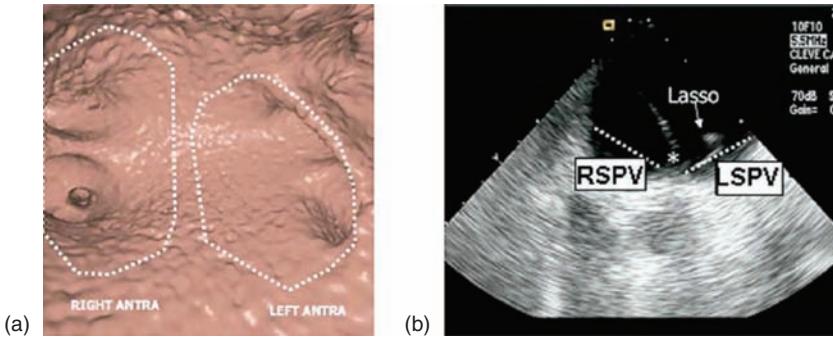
Anatomic definition of pulmonary vein ostium and antrum using three-dimensional CT imaging (a) and ICE (b). Note that the right and left pulmonary vein antra include the posterior wall of the left atrium.
